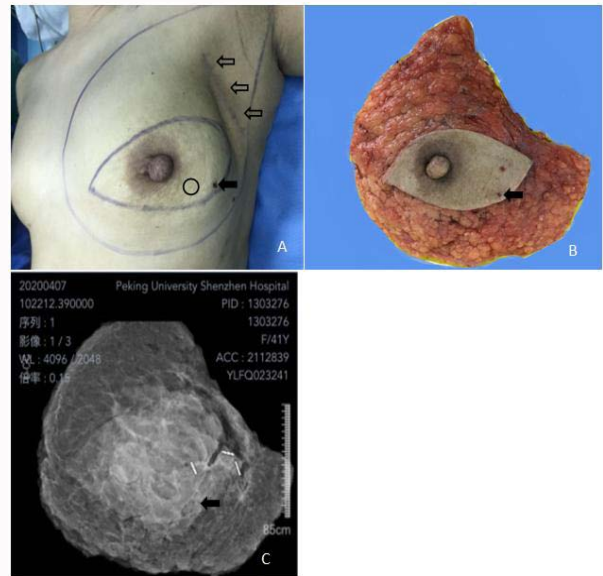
The images of left breast after Breast Conserving Surgery (BCS) and vacuum assisted breast lumpectomy (Mammotome). Panel A: The outlook of patient's left breast. Left BCS and left axillary Sentinel Lymph Node Biopsy (SLNB) skin scar was in the outer-upper quadrant near axilla (black hollow arrows); Mammotome skin scar in the outer-lower quadrant of left breast (black solid arrow); IMLN location was inner to the Mammotomescar (black hollow circle). Panel B: Resected breast after mastectomy. Part of outer-upper quadrant of breast defect due to previous BCS. Mammotome scar (black solid arrow) was included in resected skin flap. Panel C: Resected breast X-ray scan found no residue cancer. Three metal clips marked the margin of the breast after BCS. Mammotome scar was labelled in the skin flap (black solid arrow), but vacuum resected area could be hardly recognized in the X-ray image.
